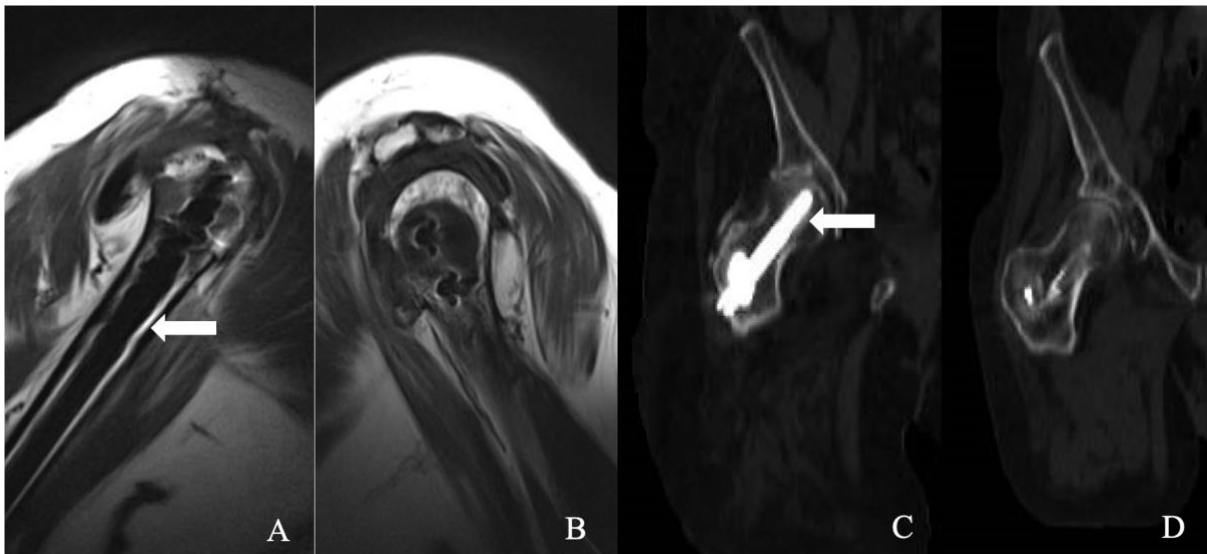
Follow-up MRI (T1 Sagittal view) of right humerus with a titanium IM nail in-situ, showing presence of artefact. B) Follow-up MRI (T1 Sagittal view) of left humerus of the same patient with a CFR-PEEK IM nail in-situ, showing the lack of artefact. C) Follow-up CT of right pelvis of a patient with a metal femoral IM nail in-situ, showing presence of artefact. D) Follow-up CT of right pelvis of a patient with a CFR-PEEK femoral IM nail in-situ, showing lack of artefact.
